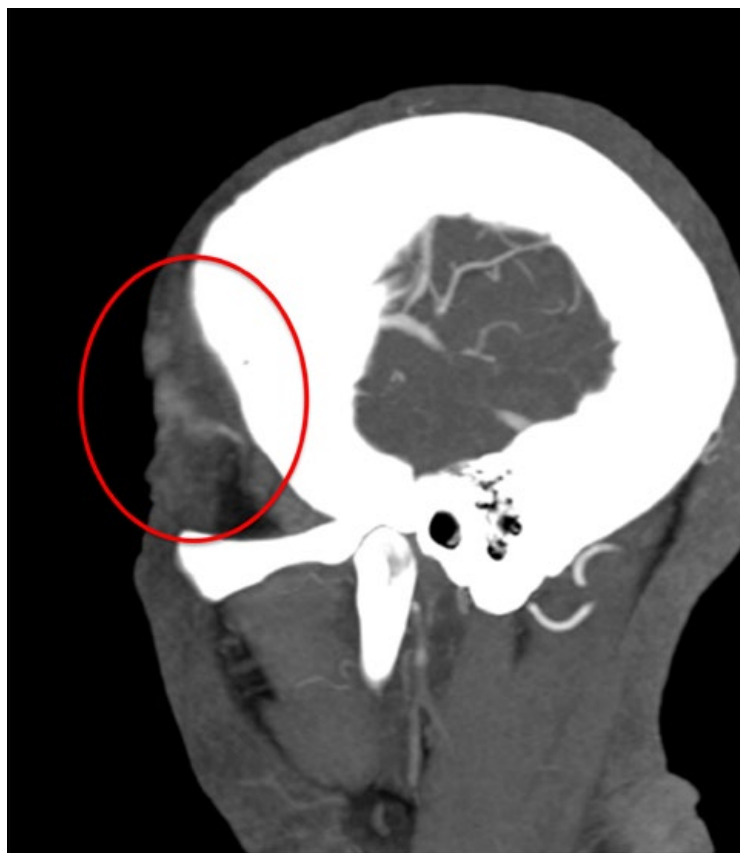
The characteristic appearance of giant cell arteritis of temporal artery on CT angiogram.
